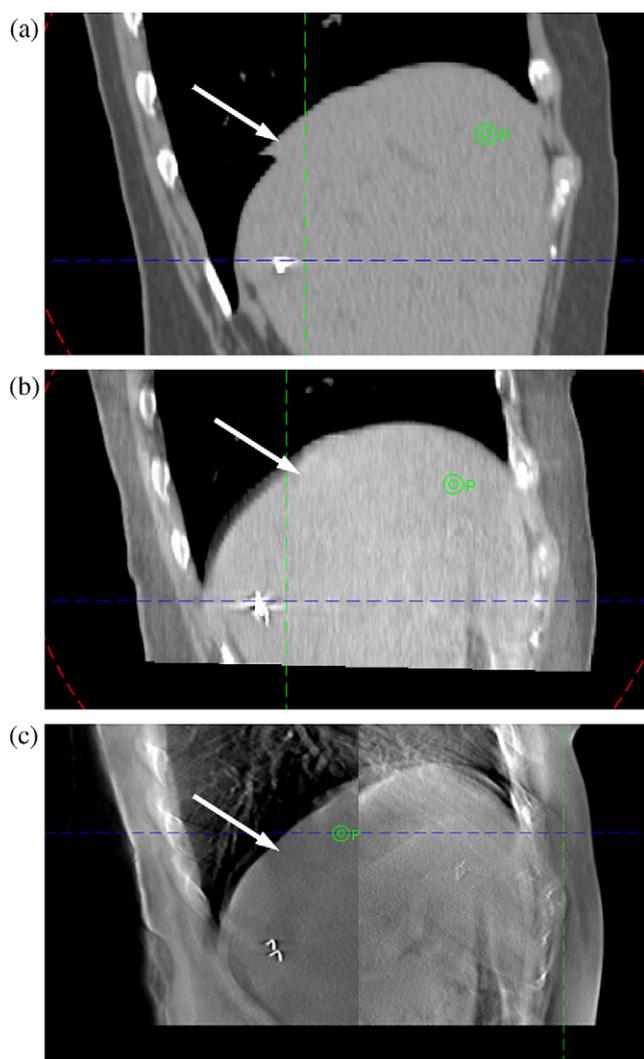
Breath-hold variability artifacts for different imaging modalities: (a) CT, (b) cone-beam CT, and (c) digital tomosynthesis.
